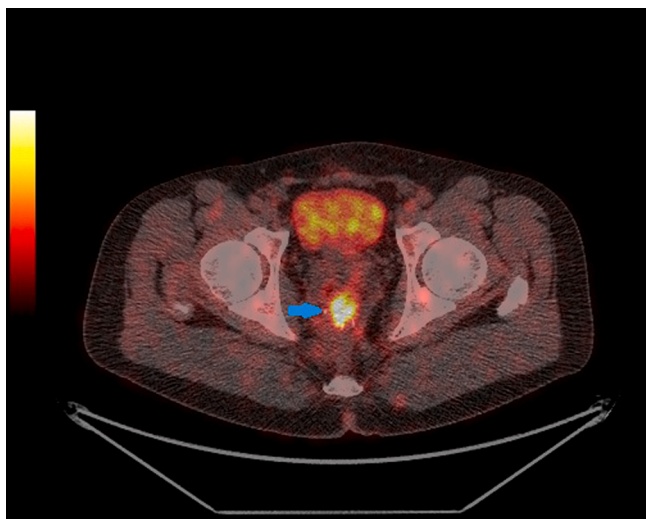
62 year old male patient with moderately differentiated adenocarcinoma of the colon with follow up anatomic imaging showing indeterminate/equivocal/ suspicious changes at site of rectal anastomosis and subsequent FDG PET/CT showing increased uptake which was determined as false positive due to post treatment changes as shown by biopsy.
